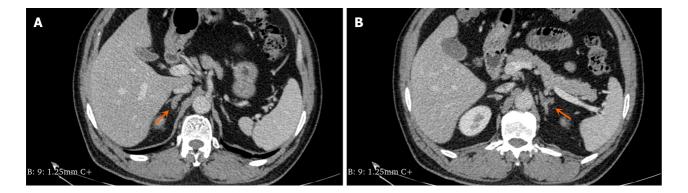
Contrast-enhanced computed tomography of bilateral adrenal glands. A: Imaging of the right adrenal gland; B: Imaging of the left adrenal gland.
